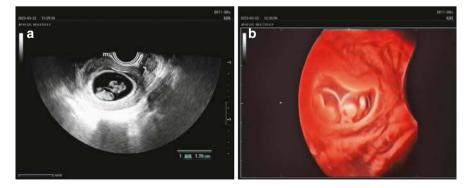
(a) MCDA twin pregnancy: One gestational sac is visible in the uterine cavity, with two amniotic sacs, each containing an embryonic bud. (b) MCDA twin pregnancy: 3D ultrasound shows one gestational sac in the uterine cavity, with two amniotic sacs visible within it
